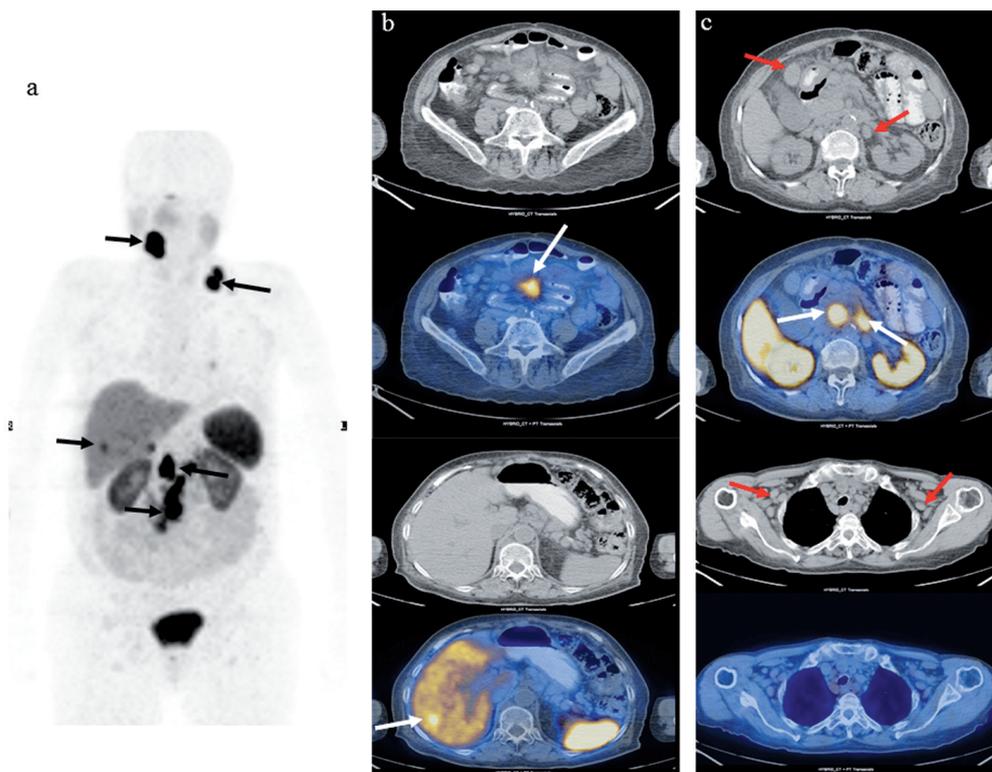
Ga-68 DOTATATE PET-CT images revealed high Ga-68 DOTATATE uptake in mesenteric, paraaortic, right upper cervical, left supraclavicular, lymph nodes (SUV max:21) and few foci in liver (a: black arrows in maximum intensity projection images, b-c: white arrows in low dose CT and fusion PET-CT). Additionally there were lymph nodes in neck, axillary spaces, intra-abdominal and inguinal bilaterally which show no tracer uptake (b-c red arrows in low dose CT part of PET-CT).
